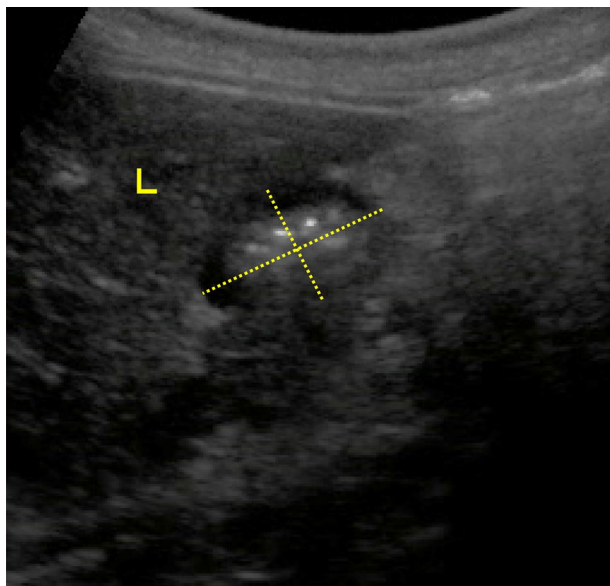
Ultrasonographic image of the antral cross-sectional area. Two dashed lines indicate anteroposterior and craniocaudal diameter, respectively, including the full thickness of the gastric wall. *L* liver
